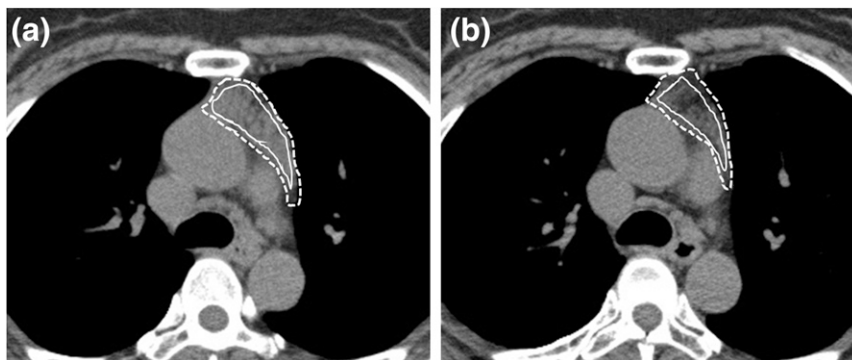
Axial CT images of a patient at the level where the thymus appears most prominently before (a) and after (b) I-131 therapy. The thymic area (dotted line) of each slice and density (solid line) were measured by the freehand ROI method.
